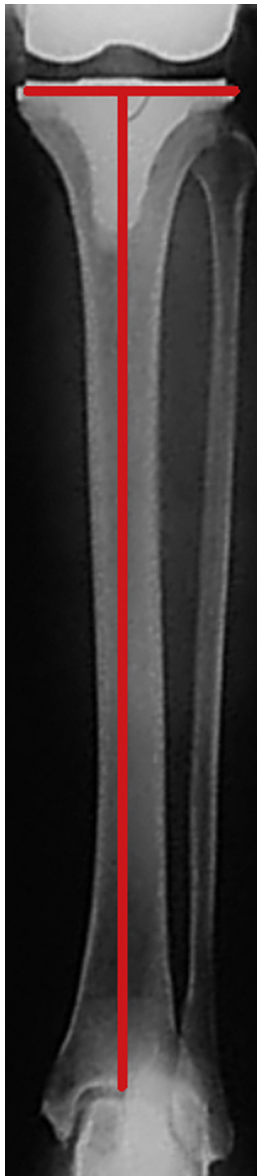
Tibial component angle (TCA) measured on a postoperative radiograph.
